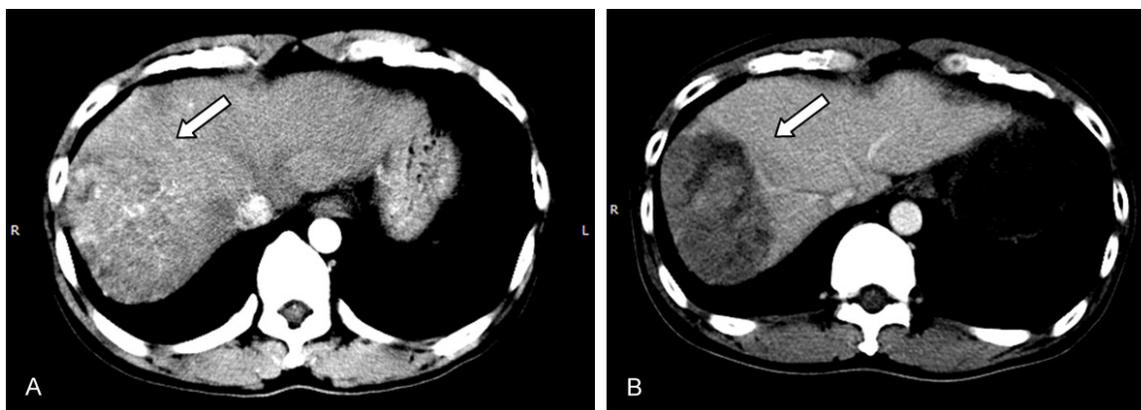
A. CT before TACE: highly intratumoral enhancement lesion in the right hepatic lobe. B. CT after TACE: disappearance of any intratumoral enhancement in target lesion.
